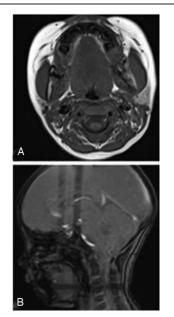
(A, B) Postoperative magnetic resonance imaging.
